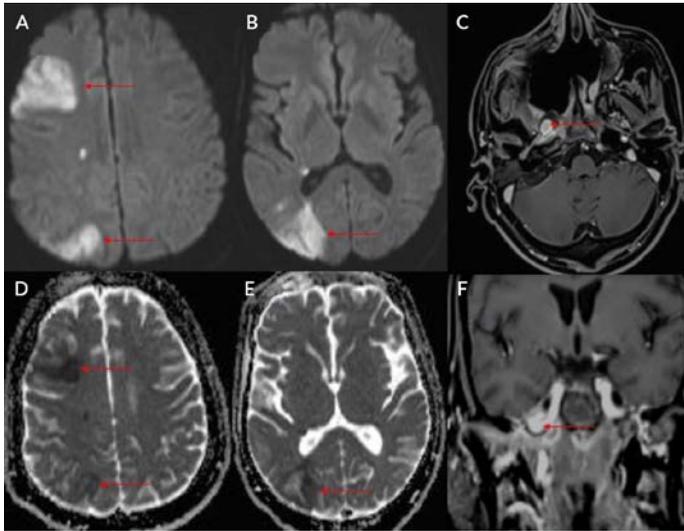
Internal carotid artery pseudoaneurysm. (A) and (B) Axial magnetic resonance imaging (MRI) images diffusion-weighted imaging sequence shows areas of diffusion restriction involving right frontal, parietal, and occipital lobes. (D) and (E) Corresponding areas of low apparent diffusion coefficient are noted, suggestive of the infarct. (C) and (F) Post-contrast MRI axial and coronal images show a pseudoaneurysm arising from the lacerum part of the right internal carotid artery.
